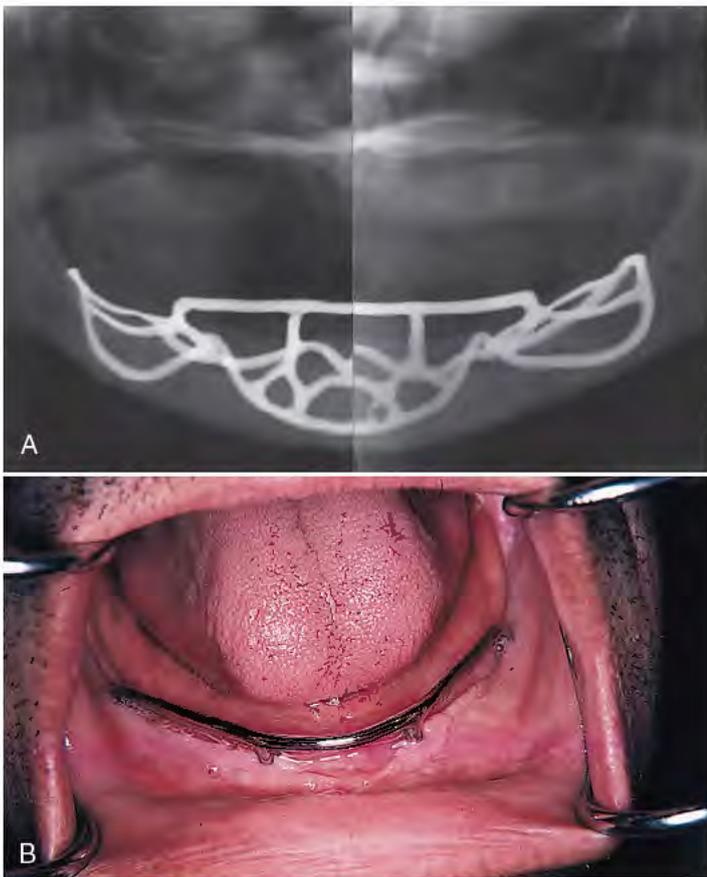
A, A Panorex radiograph of a completed implant shows good extension, a Brookdale bar configuration, and proper adaptation. B, Six weeks after insertion, the implant is firm, and the gingival cuffs are pink and well keratinized. Impression making may begin at this point.
